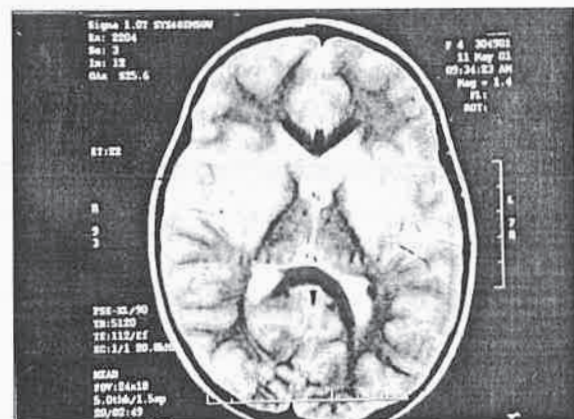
Axial T2-weighted image shows bilateral symmetrical hyperintense lesions involving the lentiform and caudate nucleus.
